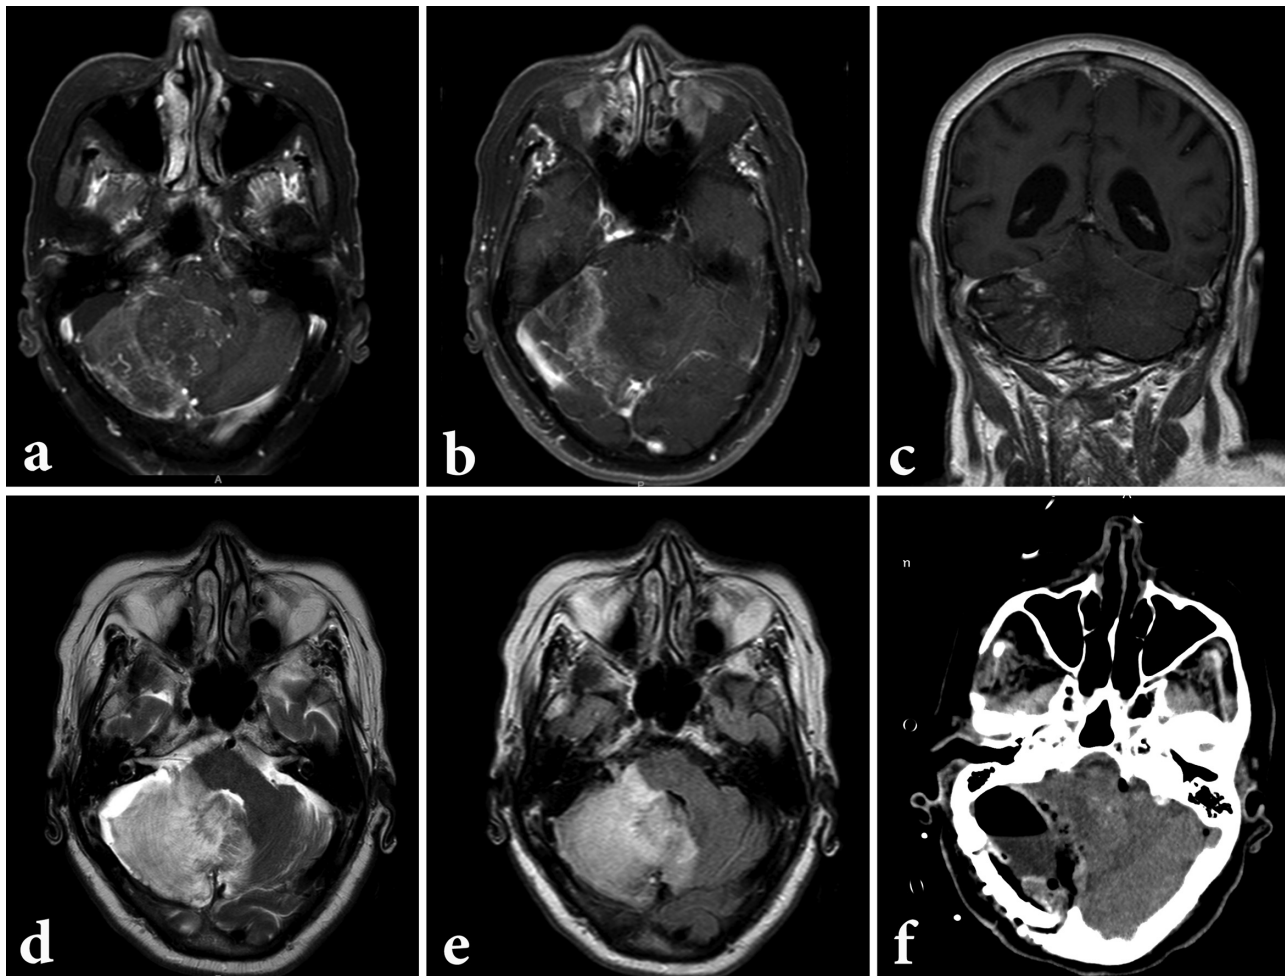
(a,b) T1-weighted axial magnetic resonance imaging (MRI) with gadolinium, evidencing extensive lesion in the right cerebellar hemisphere, with imprecise limits, moderate enhancement by the contrast and mass effect, distorting the fourth ventricle. (c) T1-weighted coronal MRI. (d) T2-weighted axial MRI. (e) fluid-attenuated inversion recovery (FLAIR) axial MRI confirming the infiltrative pattern of the lesion. (f) Post-operative axial CT scan, evidencing extensive resection of the lesion.
